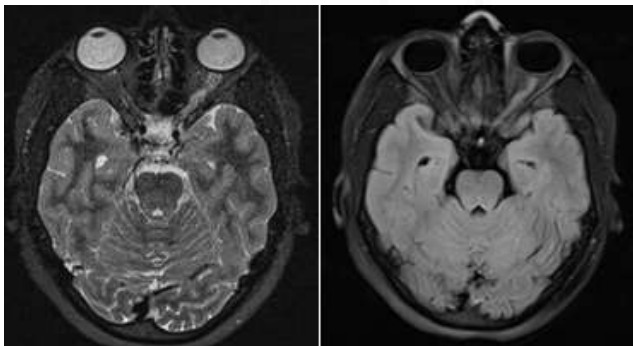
MRI orbit shows thickening of the left optic nerve with T2 and FLAIR hyperintense signal in the left optic nerve consistent with optic neuritis
